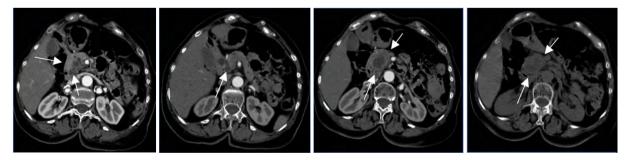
CT scan of the abdomen revealed a solid-cystic lesion located at the level of the head of the pancreas, measuring $37 \times 40 \times 55$ mm in size
